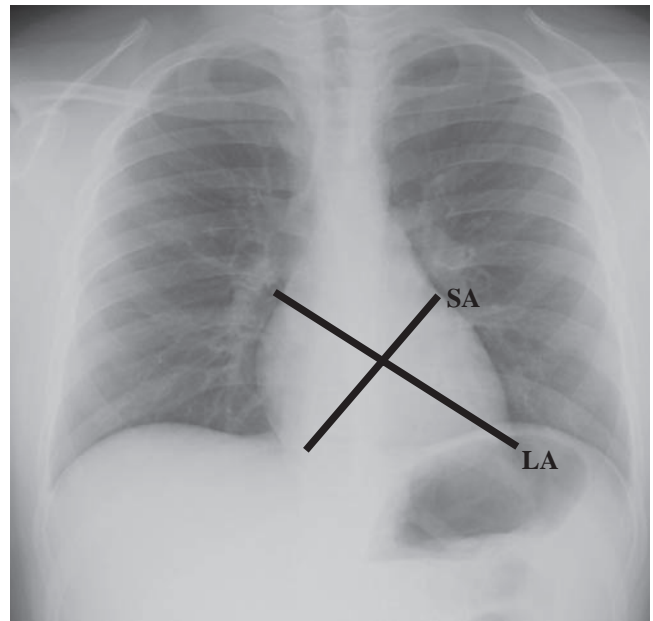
Ultrasound axes of the heart. Long axis (LA) and short axis (SA).
